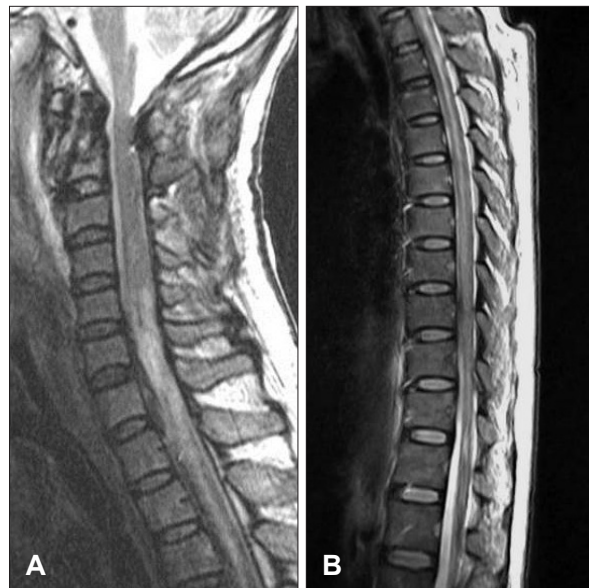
Cervical MRI revealing heterogeneous high signal intensity (consider to hemorrhagic contusion) in spinal cord of C3–T2 level (A) and extensive syringomyelia in thoracic spinal cord (B).
